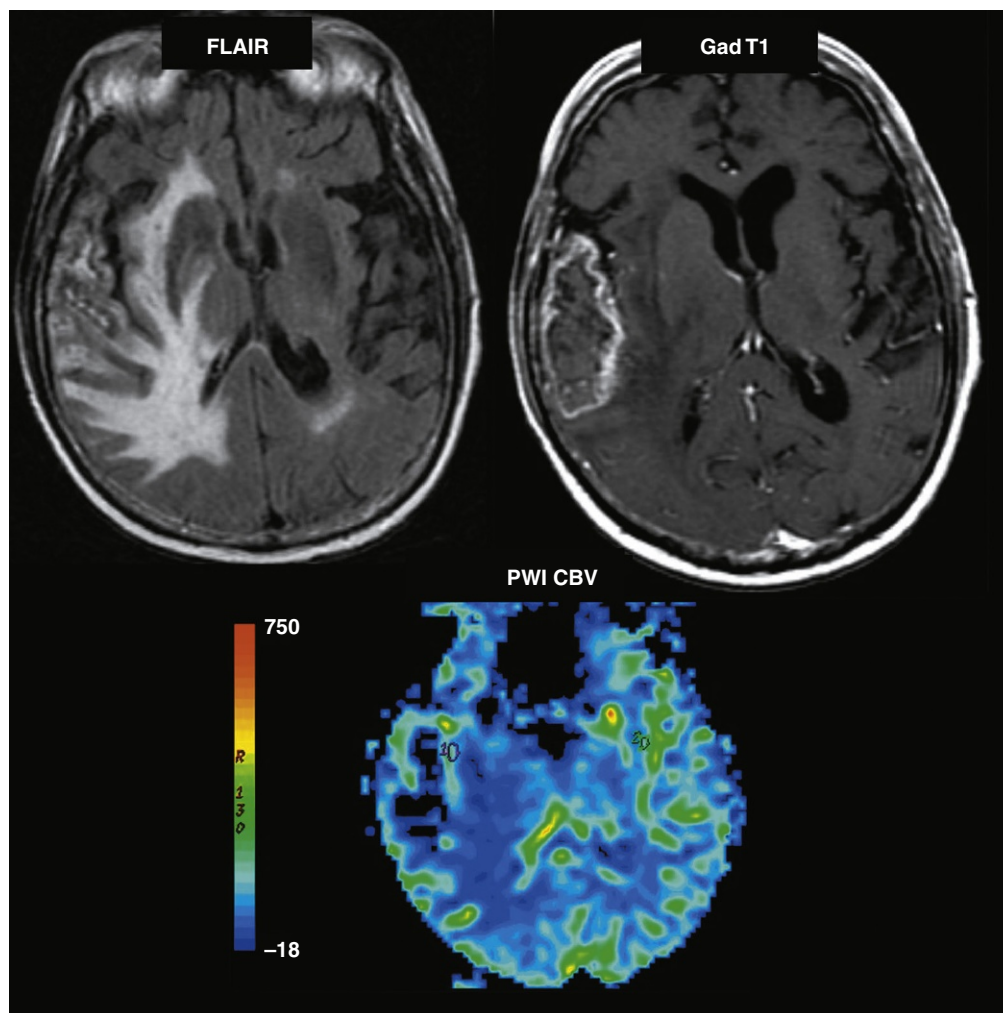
An 82-year-old male patient radiated for external ear cancer underwent a magnetic resonance imaging study that showed an abnormally enhancing lesion in the right temporal lobe, without significant mass effect. Perfusion-weighted dynamic susceptibility imaging demonstrated no increased cerebral blood volume (no red) within this lesion, confirming the suspicion of radiation necrosis based on the clinical history.
